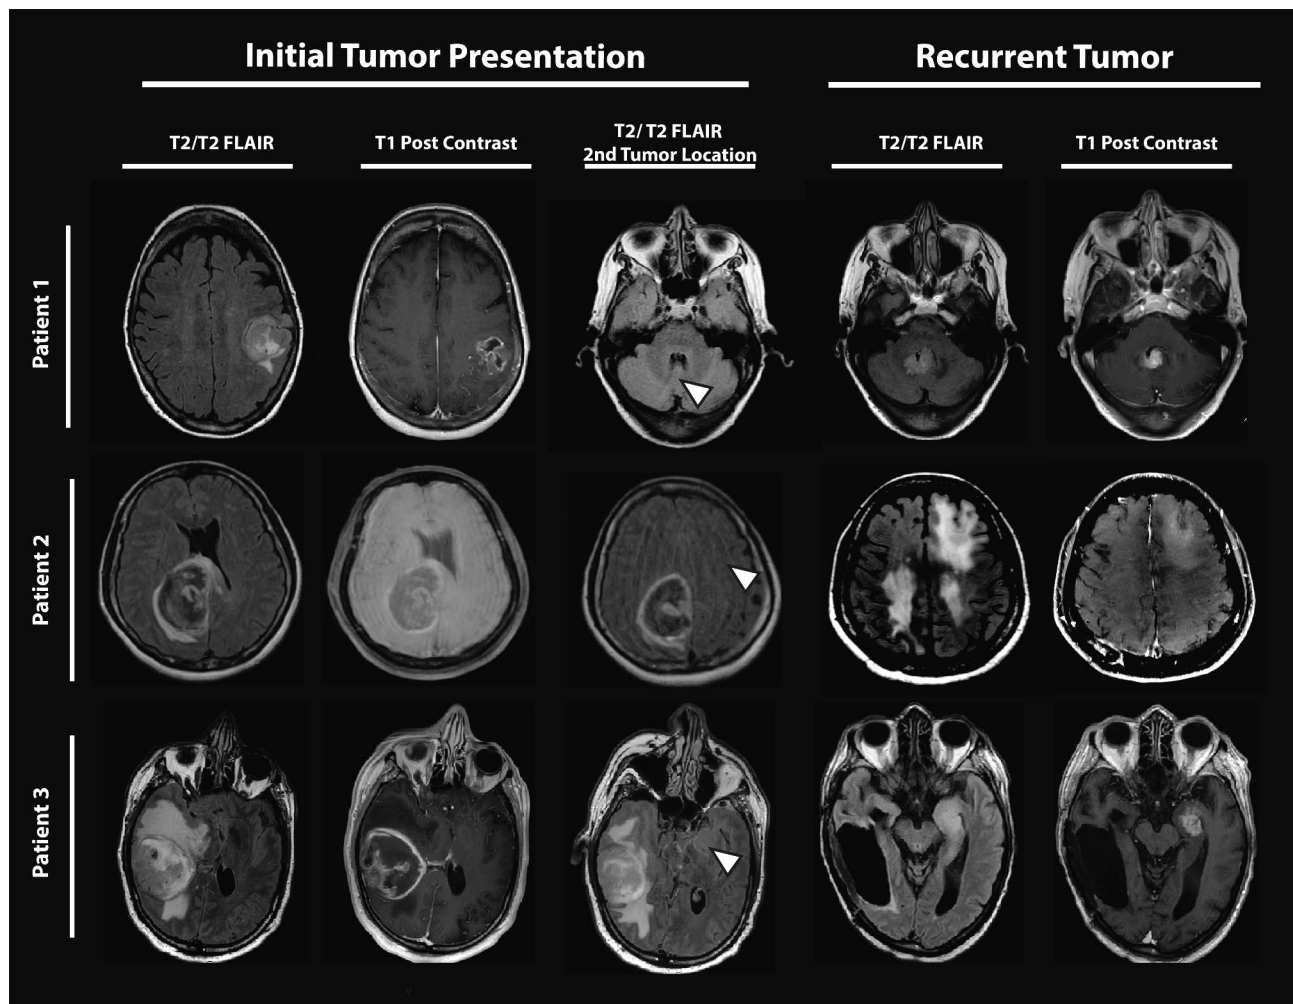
Brain MRI findings in patients with discontinuous IDH-wildtype GBM recurrence. Pre-operative MRI at initial presentation shows enhancing disease at the site of the initial tumor (left 2 panels) but no sign of disease at the future location of the recurrent tumor (middle panel). A follow up MRI (right 2 panels) shows development of a discontinuous recurrence at this location
